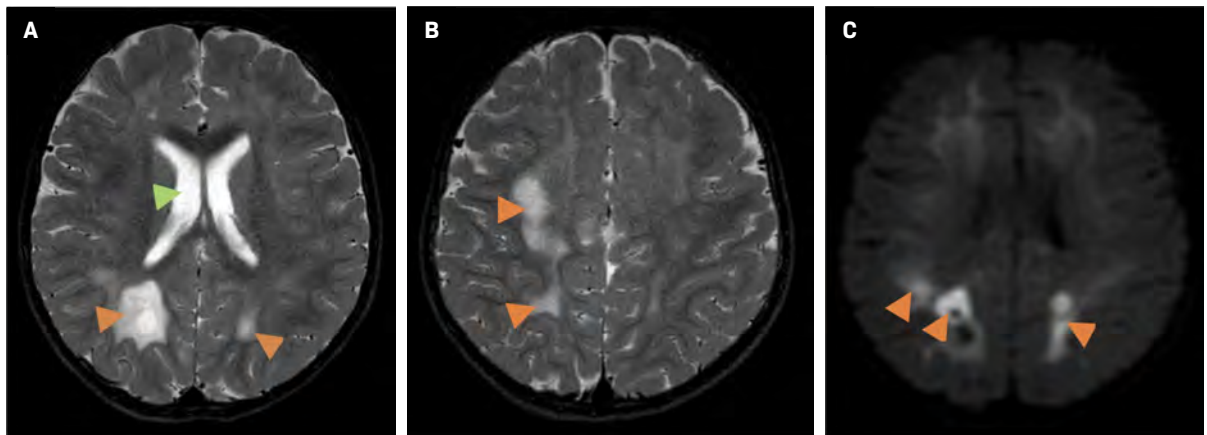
Brain MRI one year later. Axial T2 (A, B) demonstrates progressive abnormal white matter signal hyperintensity (orange arrowheads) and an interval ventricular enlargement (A, green arrow). Axial DWI (C) shows worsening restricted diffusion (orange arrowheads).
